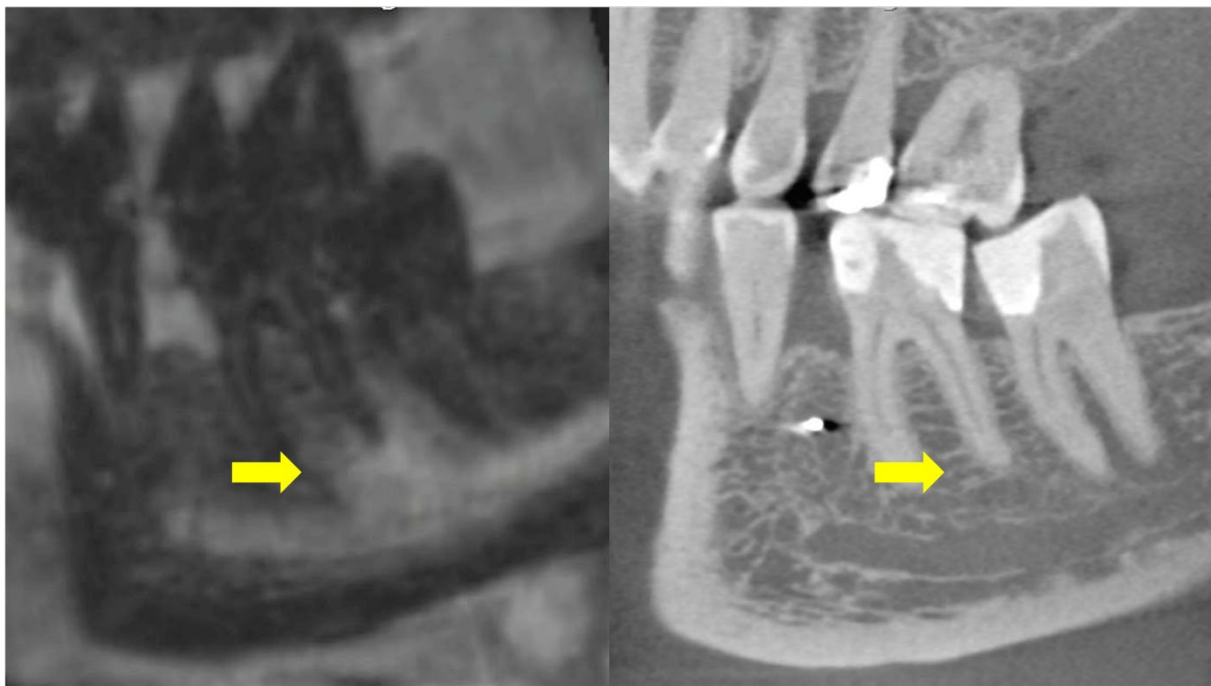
Periapical lesion detected in T1KM (a) and absent in CBCT (b)
